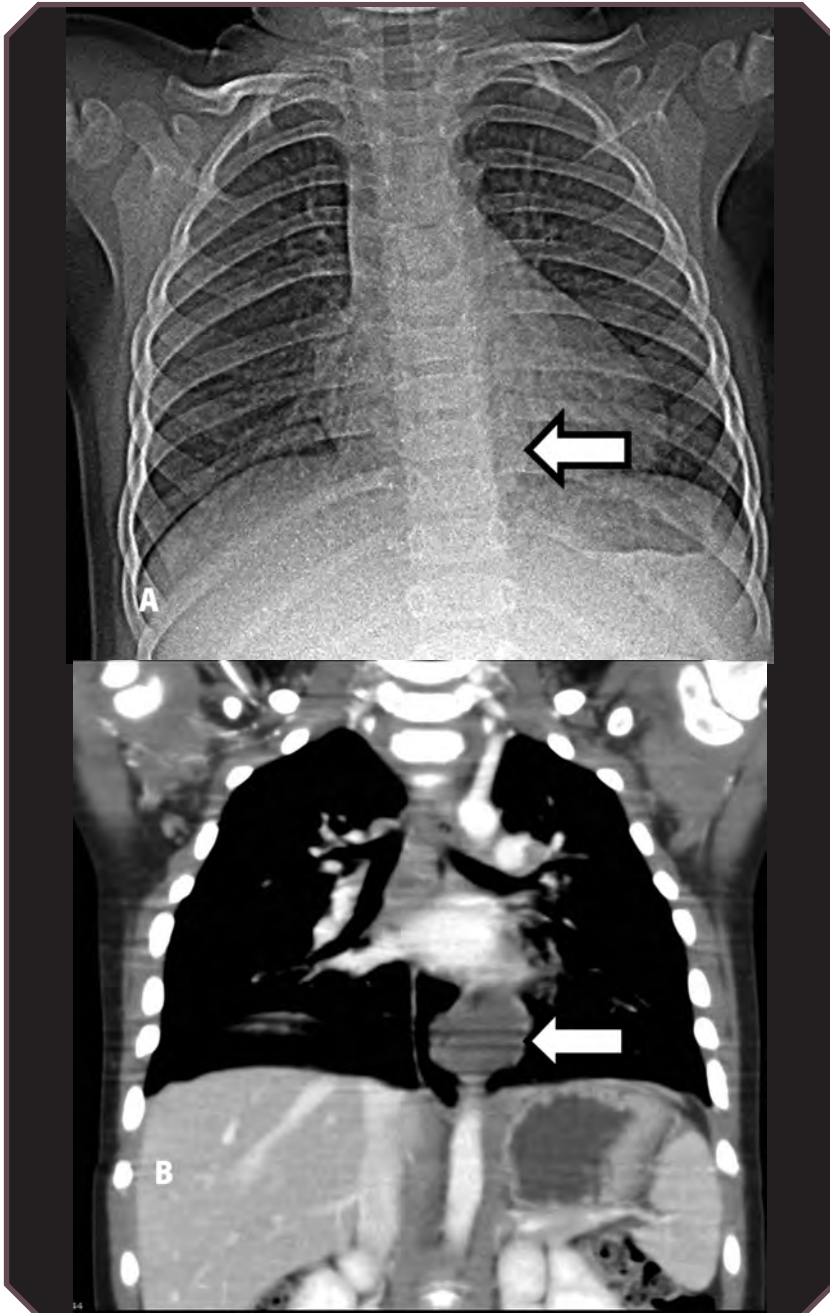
Esophageal duplication cyst in a 2-year-old girl. A. Posteroanterior radiograph of the chest shows a subtle, well-defined retrocardiac opacity (arrow). B. Coronal reconstruction from contrast-enhanced computed tomography confirms a low-attenuation lesion (arrow) typical for a duplication cyst. The cyst was surgically resected.
